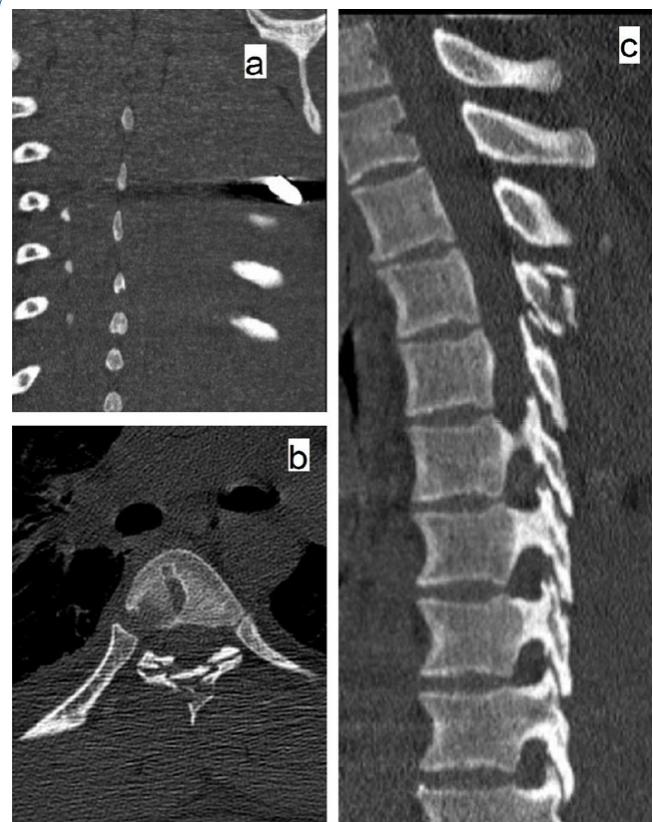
a: Coronal section of thoracic vertebrae CT, showing the bullet in paravertebral muscles at the level of T9; b: Axial section of T7 CT, showing T7 posterior element fracture, and c: Sagittal section of thoracic vertebrae CT, showing T7 posterior element fracture.
